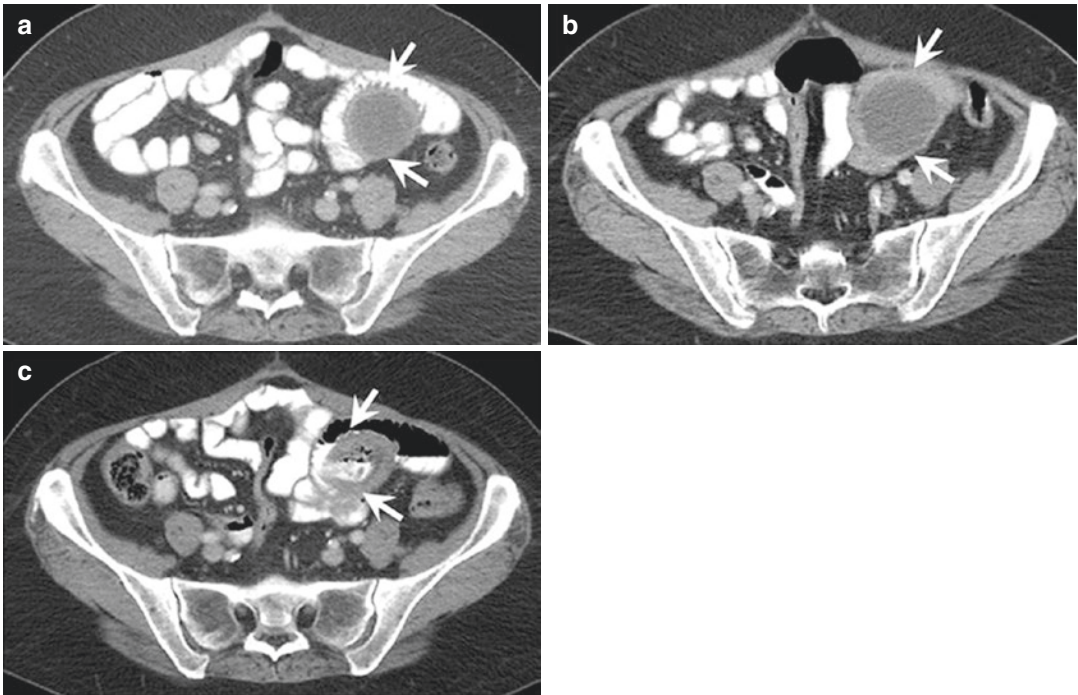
A 73-year-old woman with metastatic leiomyosarcoma on sunitinib. (a, b) Axial contrast-enhanced CT images obtained at baseline and 1 month after the start of treatment demonstrate a decrease in the thickness of the enhancing wall of the metastatic deposit in the small bowel mesentery (arrows) in spite of slight increase in size, suggestive of partial response to treatment. (c) Axial
